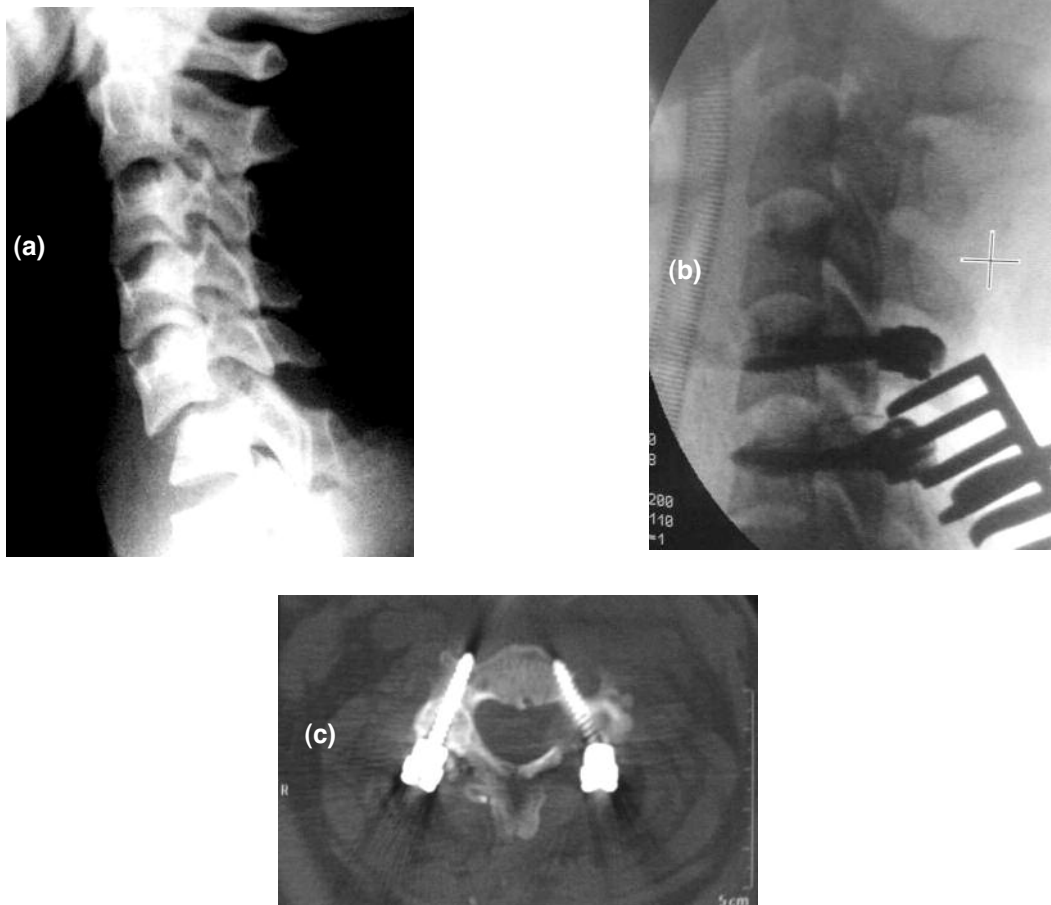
Case 9. (a) Preoperative direct x-ray showing fracture-dislocation in C5-C6 level. (b) Postoperative sagittal CT scan demonstrating at the final follow-up examination, showing autologous iliac graft, and well maintained cervical alignment. (c) Postoperative axial CT demonstrating incorrect screw placement (Grade 3) at the right foramen transversarium.
